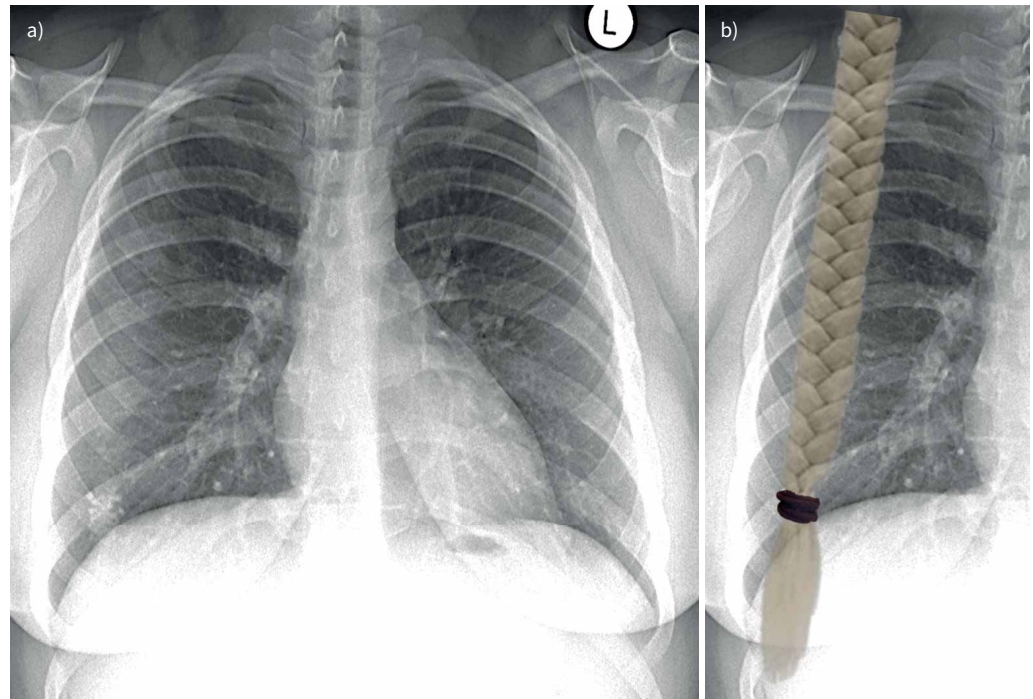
a) Chest radiograph; b) chest radiograph with plait superimposed.
